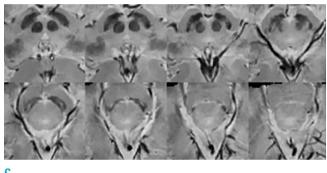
Representative MR images of our protocol. (a) Acquired five-echo magnitude and phase. Reconstructed neuromelanin (b) and nigrosome (c) images.
